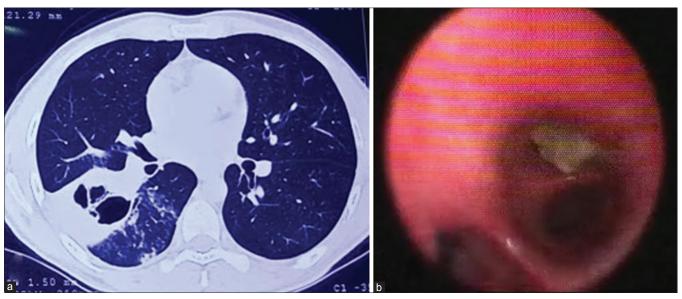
(a) Computed tomographic thorax demonstrating cavitary lesion in the right lower lobe, (b) bronchoscopic appearance of plug occluding the lower lobe segment
